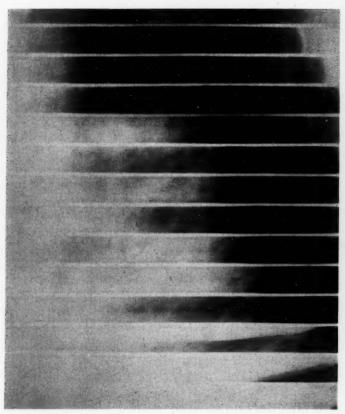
B. Roentgenkymogram of left ventricular border revealing abnormal pulsations in the region of the aneurysm.
